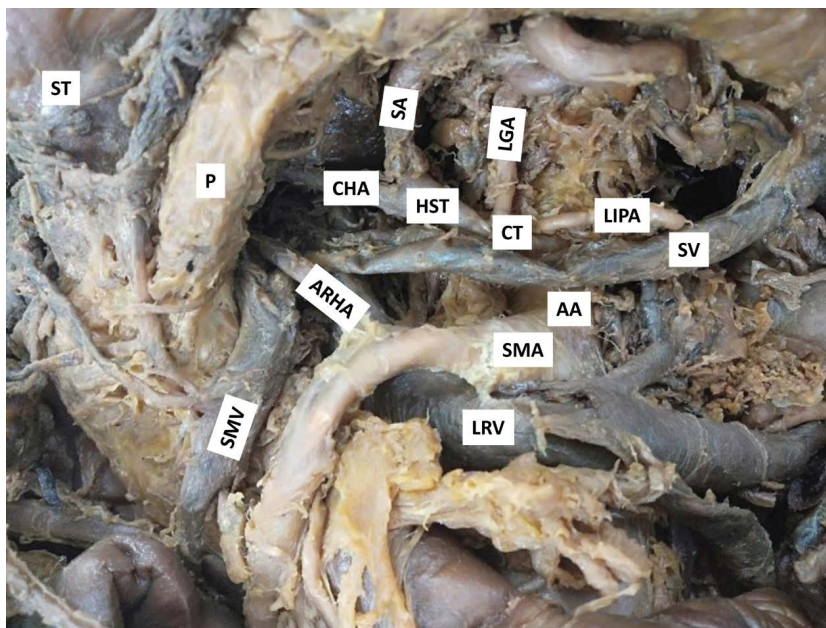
Accessory right hepatic artery (ARHA) arising from the superior mesenteric artery (SMA) in the pancreatic bed. The stomach (ST) and pancreas (P) are retracted to show the variation; AA — abdominal aorta; CHA — common hepatic artery; CT — coeliac trunk; HST — hepatosplenic trunk; LGA — left gastric artery; LIPA — left inferior phrenic artery; LRV — left renal vein; SA — splenic artery; SMA — superior mesenteric artery; SMV — superior mesenteric vein; SV — splenic vein.
